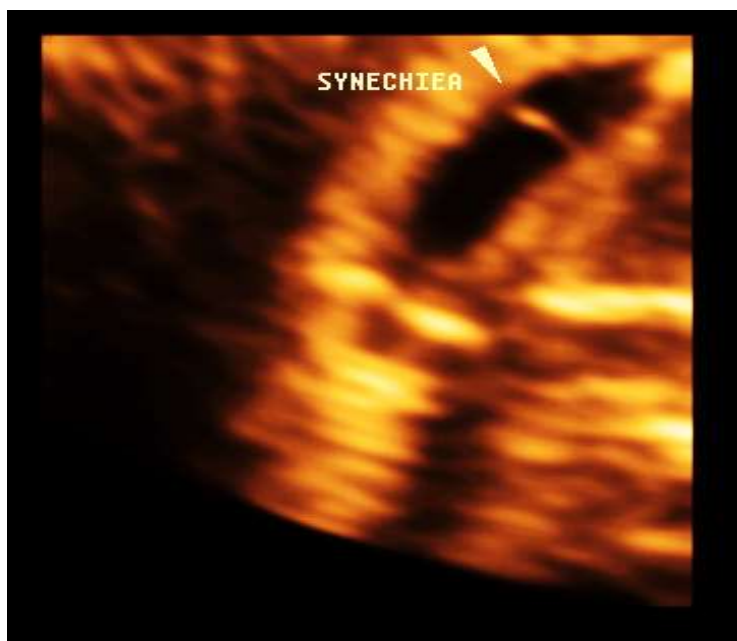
3D ultrasound surface rendering of mild endometrial cavity adhesions.
